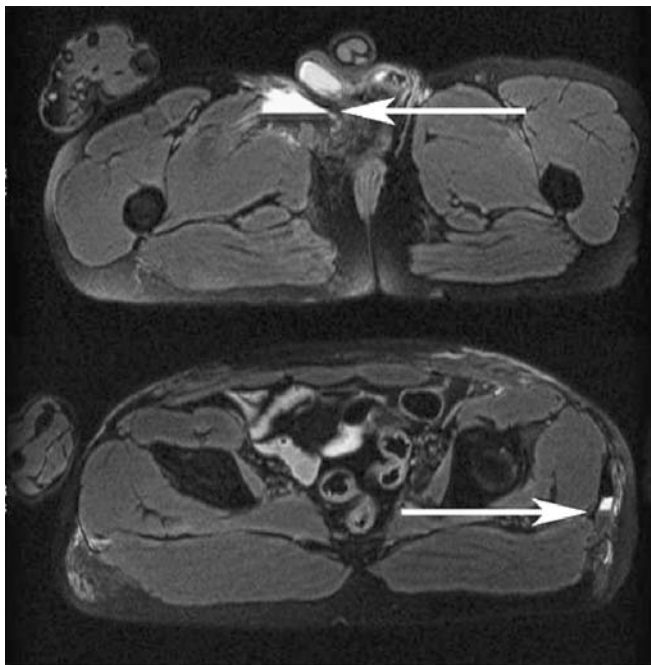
Axial T2-weighted pelvic MR images (TE 96 ms, TR 4,000 ms) of blood-filled wound cavities (*décollements*) in a pedestrian/vehicle accident. Sedimentation and fluid levels (*arrows*) within the subcutaneous tissue are visible as a postmortem radiological hint for wound cavities
